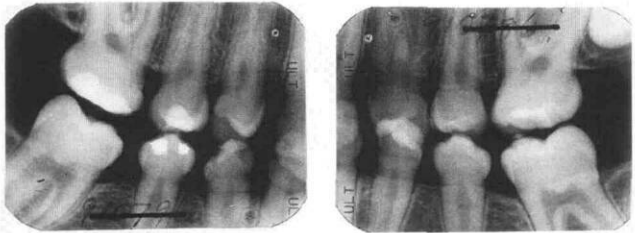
Bite-wing radiographs of the patient depicted in Fig 2a, showing bulbous appearance of the crowns and constricted cervical areas due to lack of enamel at these areas of the crowns. There is also complete coronal pulp calcification.
